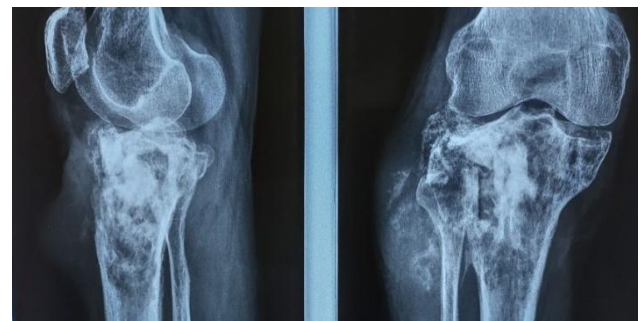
Digital Radiograph AP and LAT view showing local recurrence of GCT of proximal tibia after 4 years
